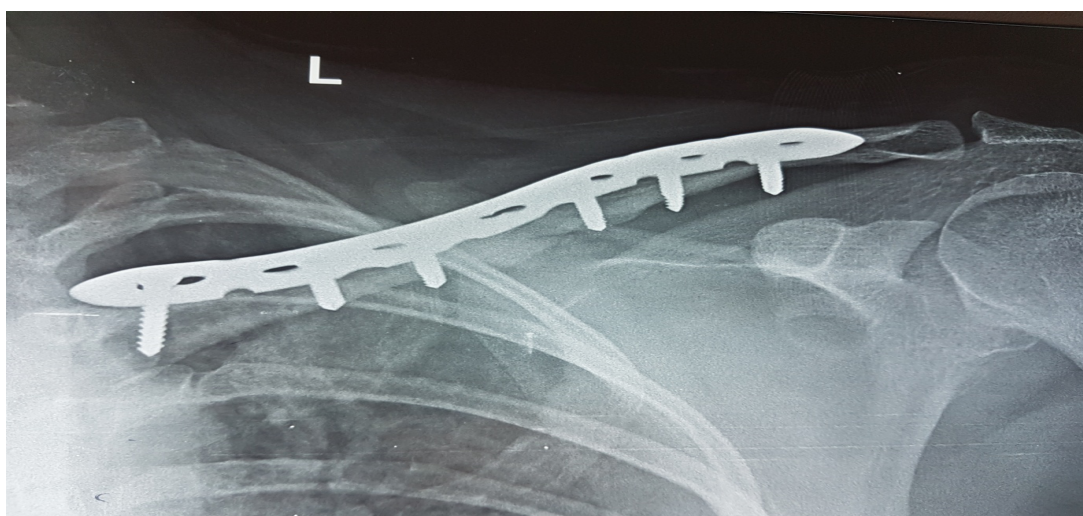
X-ray at 12 weeks
